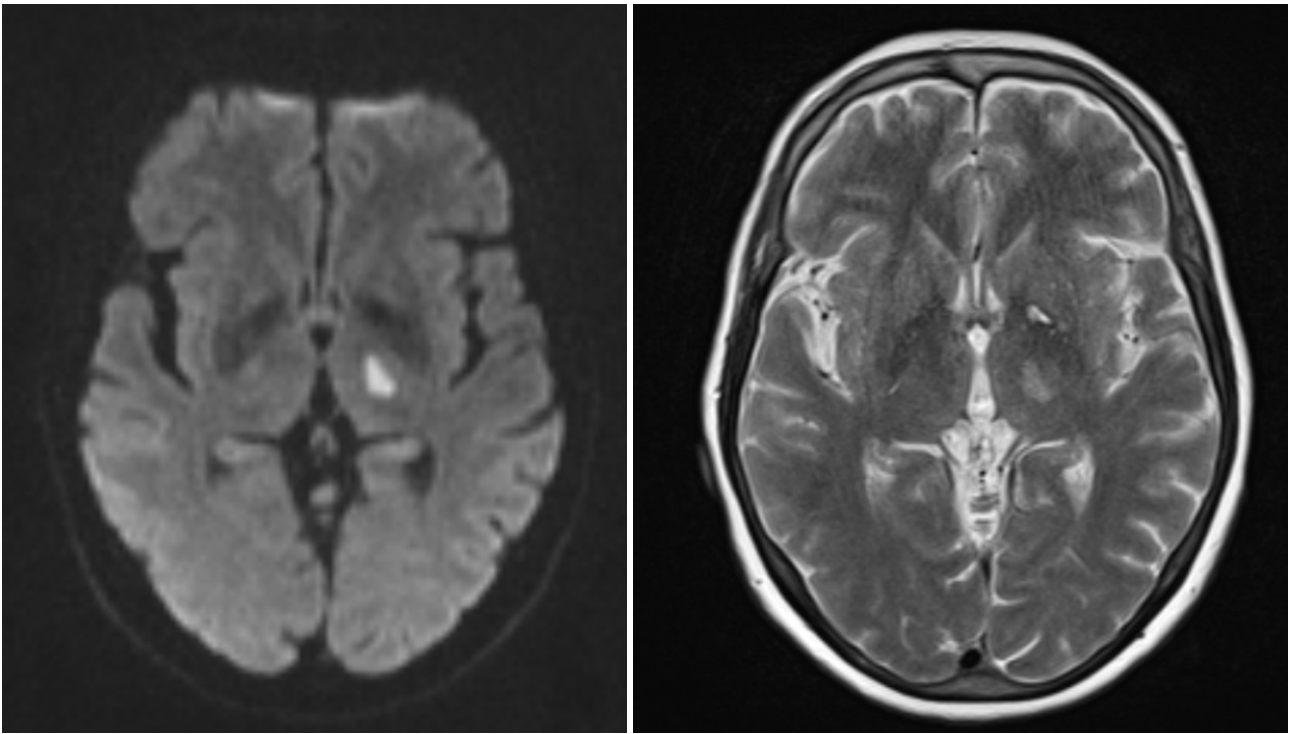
Brain MRI (diffusion weighted imaging [left] and T2 weighted [right]) showing left thalamic and internal capsule infarct.
